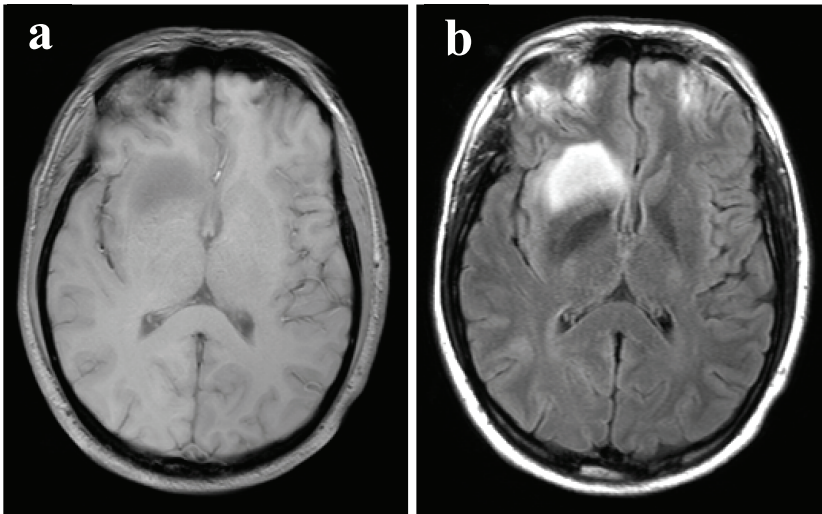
MRI of lower-grade glioma located in the right frontal lobe. 2a: T1 weighted sequence. 2b: FLAIR sequence.
